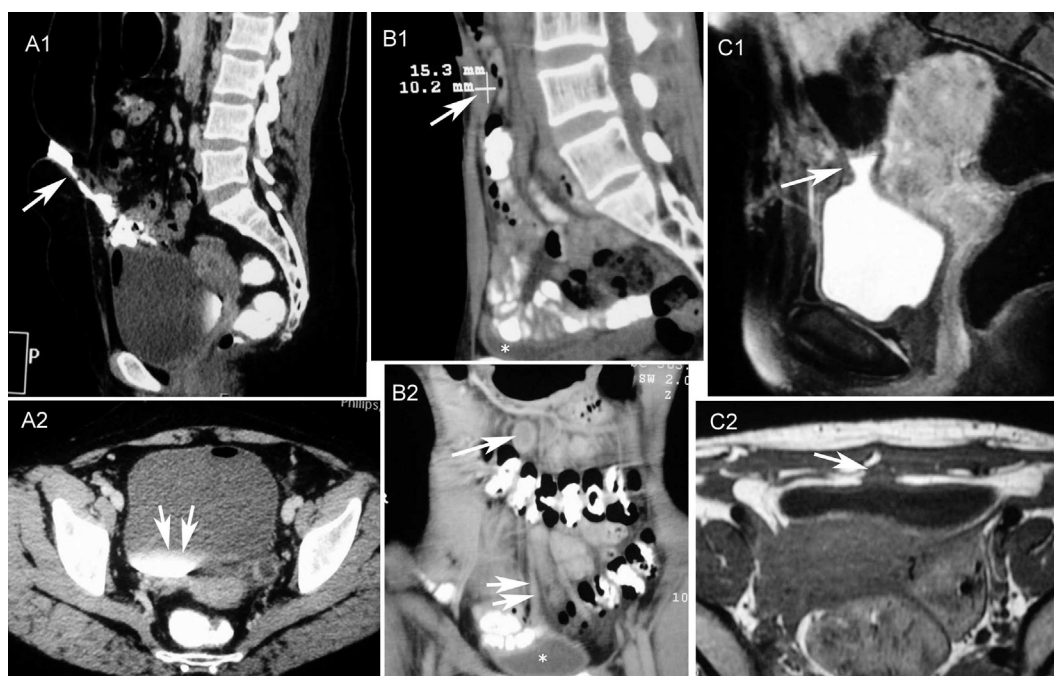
(A) Thirty year old female with watery discharge from umbilicus. Midsagittal (A1) and axial (A2) CT images with umbilical contrast instillation show patent urachus (arrow) with passage of contrast into the urinary bladder (double arrows). (B) Midsagittal (B1) and coronal (B2) CT images of a 35 year old male showing urachal cyst (arrow in B1 and B2) and thickened medial umbilical ligament (double arrow). (C) Midsagittal T2 (C1) and axial T1 (C2) MR images of a 29 year old female showing urachal umbilical diverticulum (arrow in C1) and thickened median umbilical ligament (arrow in C2). (Image courtesy – Dr. Dinesh Sood, Professor and Head, Department of radiology, DRPGMC, Kangra at Tanda, Himachal Pradesh, India).
